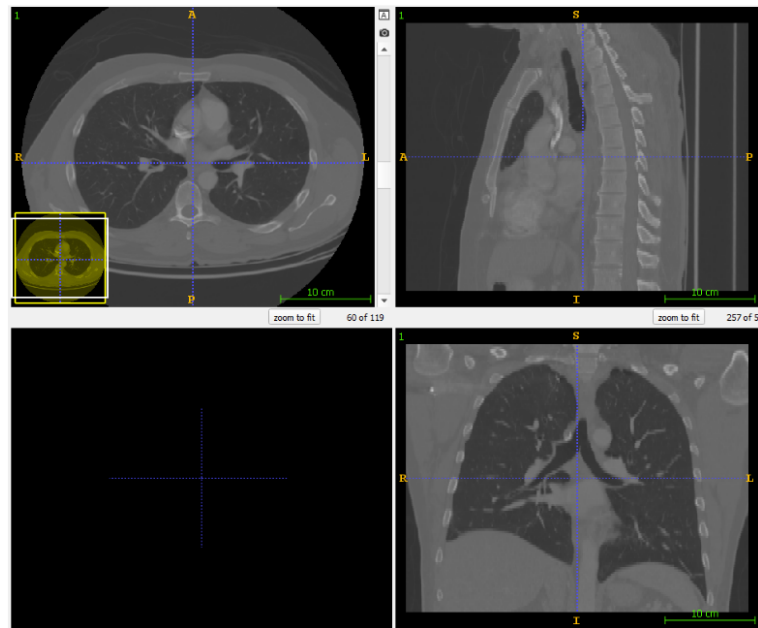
Views of a CT scan from LUNA16 challenge [27].
